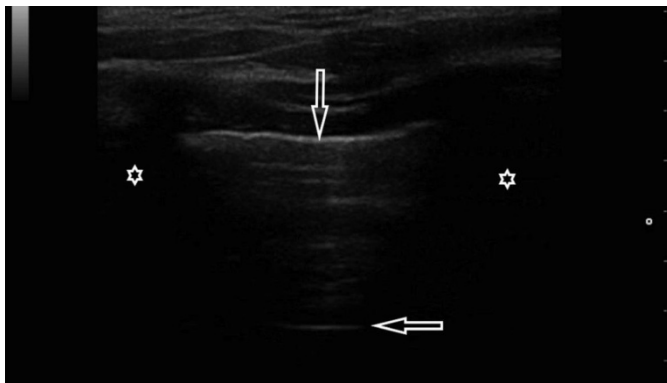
Normal ultrasound image with linear transducer: regular and echogenic pleural line (↓) and A-line (←), shadow behind the ribs (*); linear transducer⁽²¹⁾.
